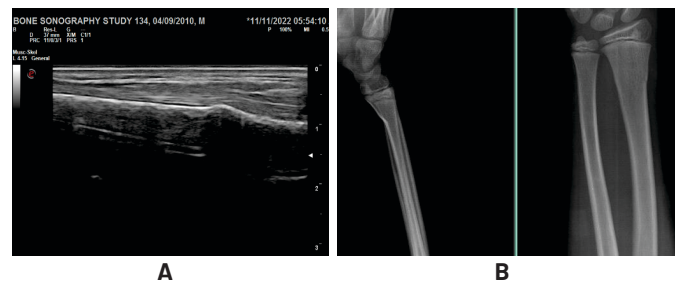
(A) cortical bulging, (B) X-Ray of the same patient
